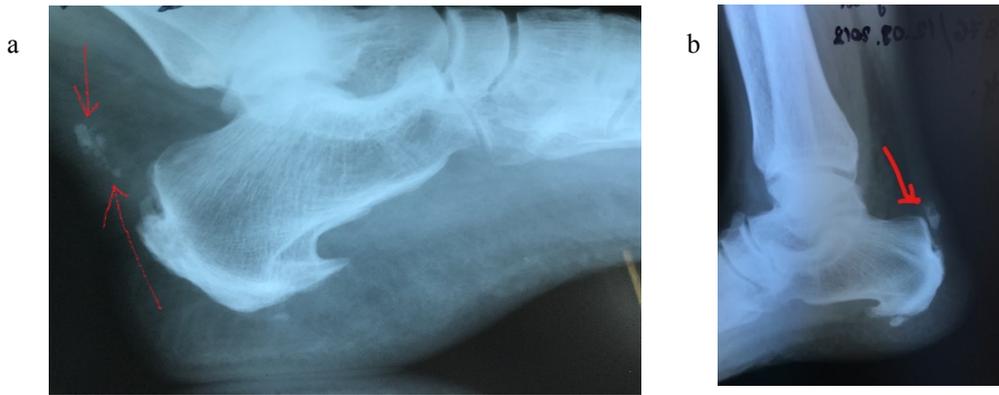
(a) X-ray image; (b) Calcification of the Achilles tendon.
